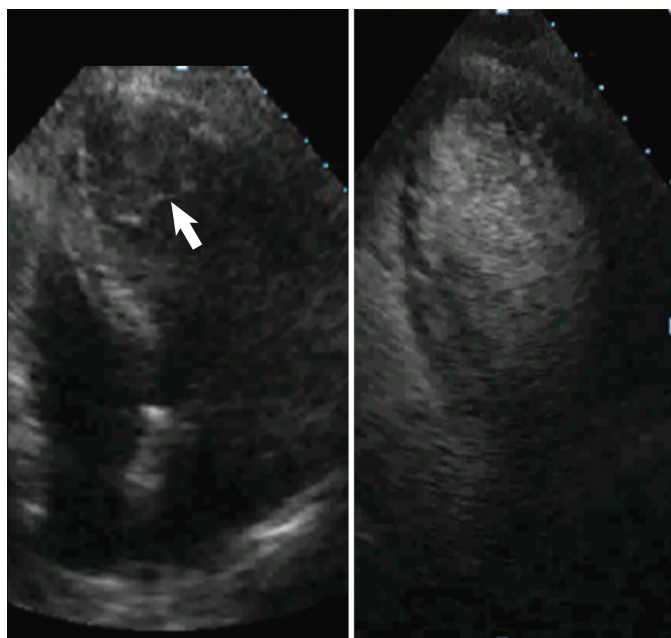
Apical four-chamber unenhanced (left panel) and enhanced (right panel) images. In the unenhanced image a thrombus-like structure is visualized in the apical region (arrow). The enhanced version shows that there is no filling defect, thus suggesting that this was an acoustic artifact and not a true thrombus.
